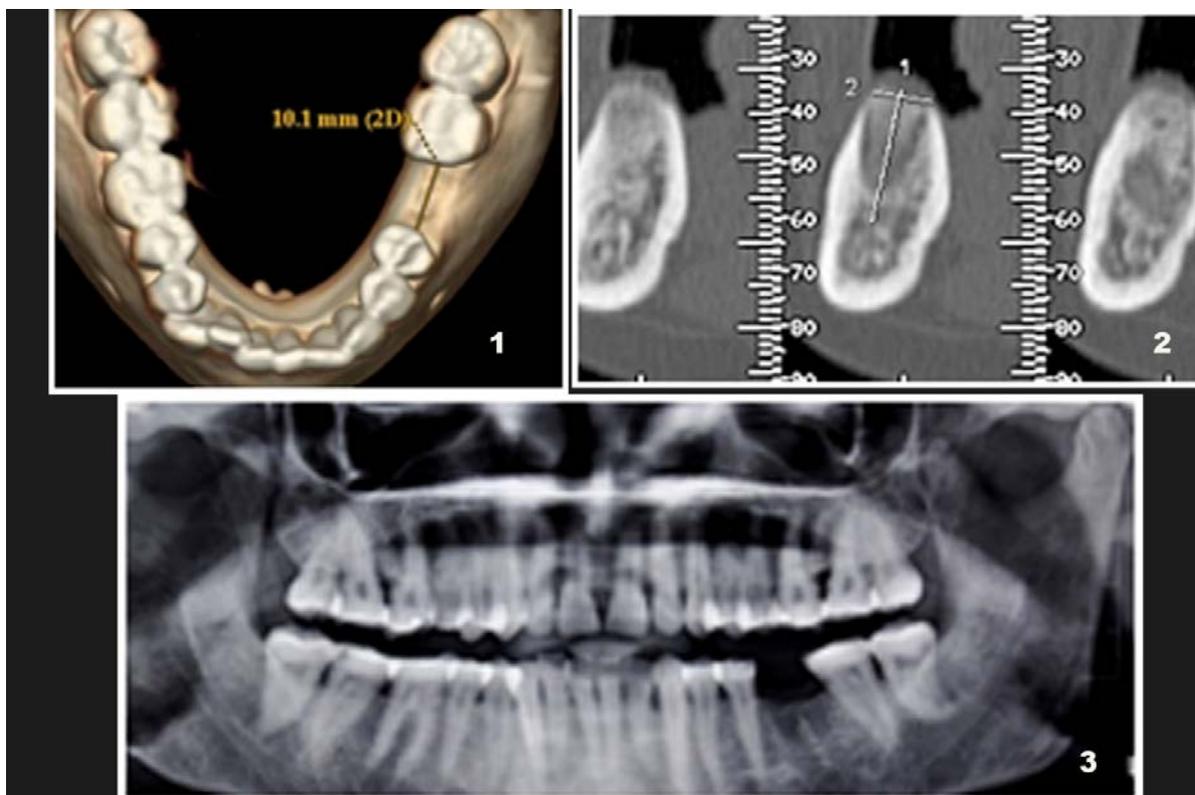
Pre Surgical Planning OPG,CT and 3D view
